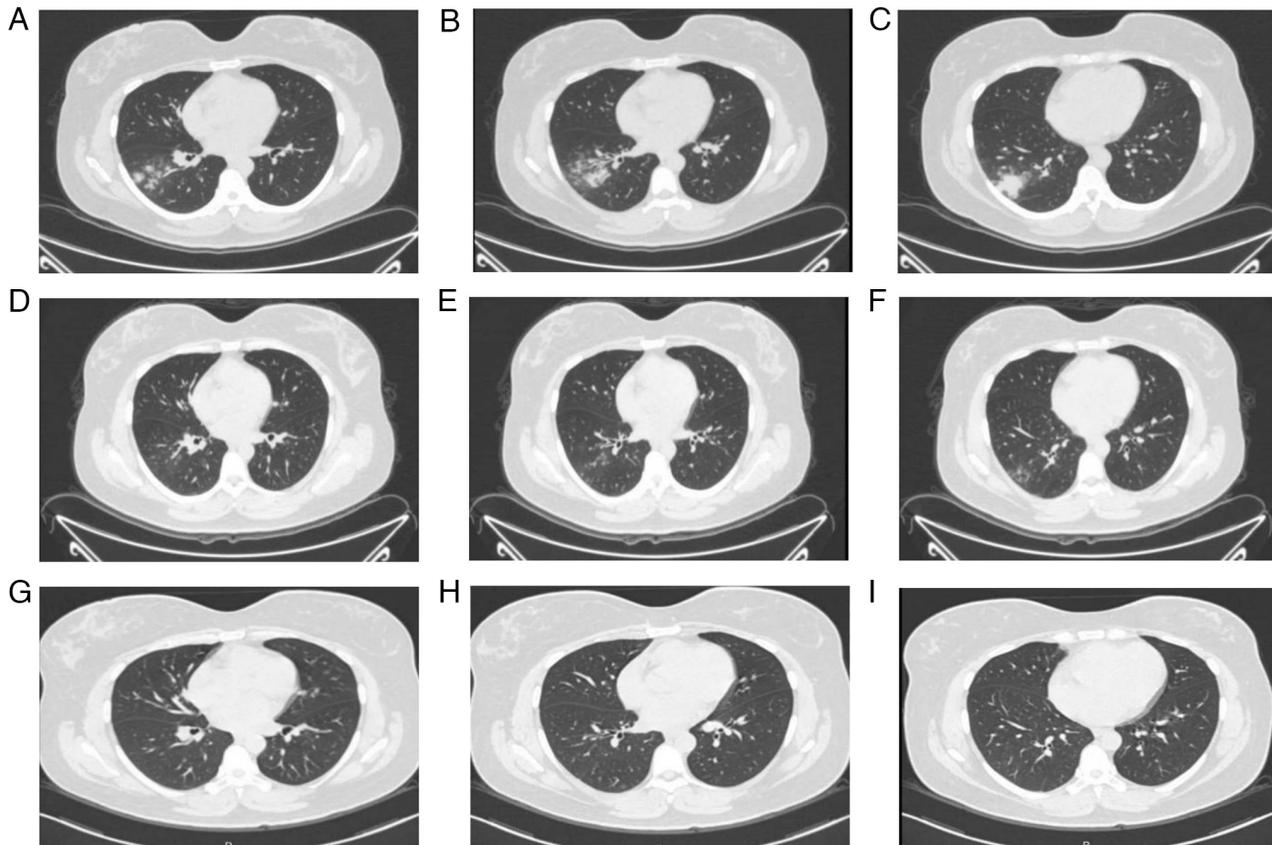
Comparison of chest CT in patient 3. (A-C) Chest CT in January 2022. (D-F) Chest CT 2 weeks later. (G-I) Chest CT in March 2022. The lesions were more clearly absorbed in March compared with at the first CT scan in January.
